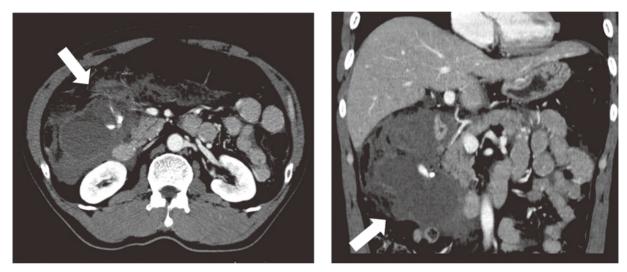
Contrasted abdominal computed tomography (CT) indicated a low density mass with extravasation.
